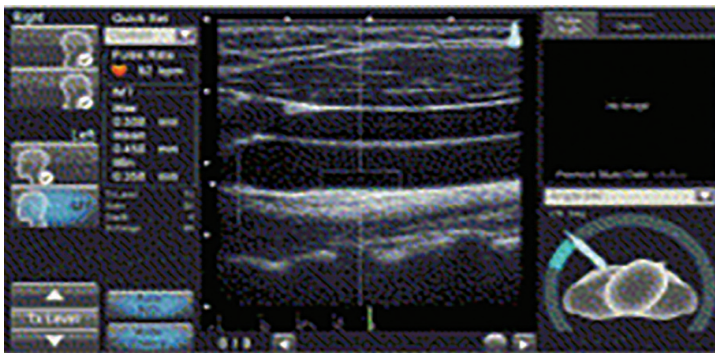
Ultrasonography of carotid arteries A
